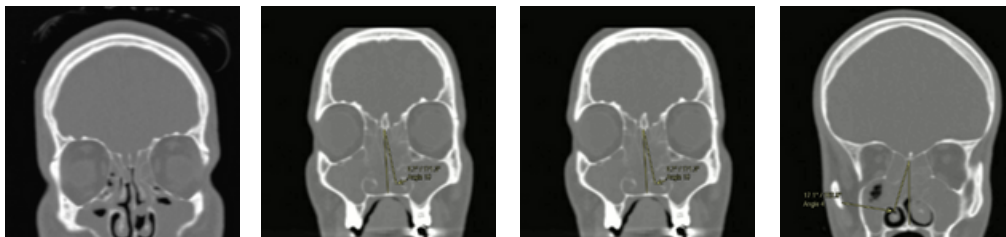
coronal CT images bone window for different patients, demonstrate partial opacification of paranasal sinuses with different degrees of nasal septal deviation, (A) Normal. (B) Mild. (C) Moderate. (D) severe.
